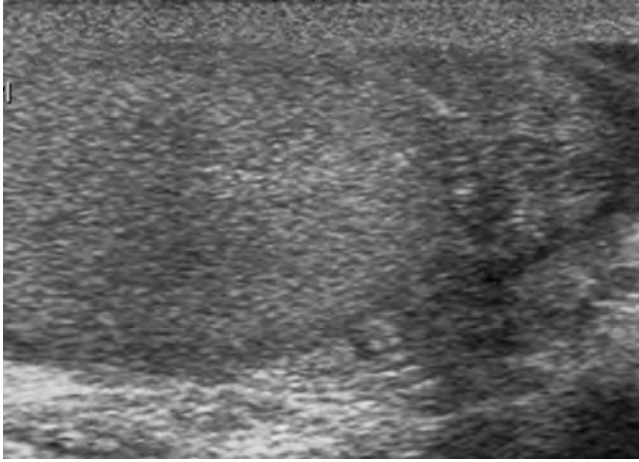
Ultrasound imaging of the caput epididymis, which appears hyperechoic to the testis and is at the right of the testis on this image.
